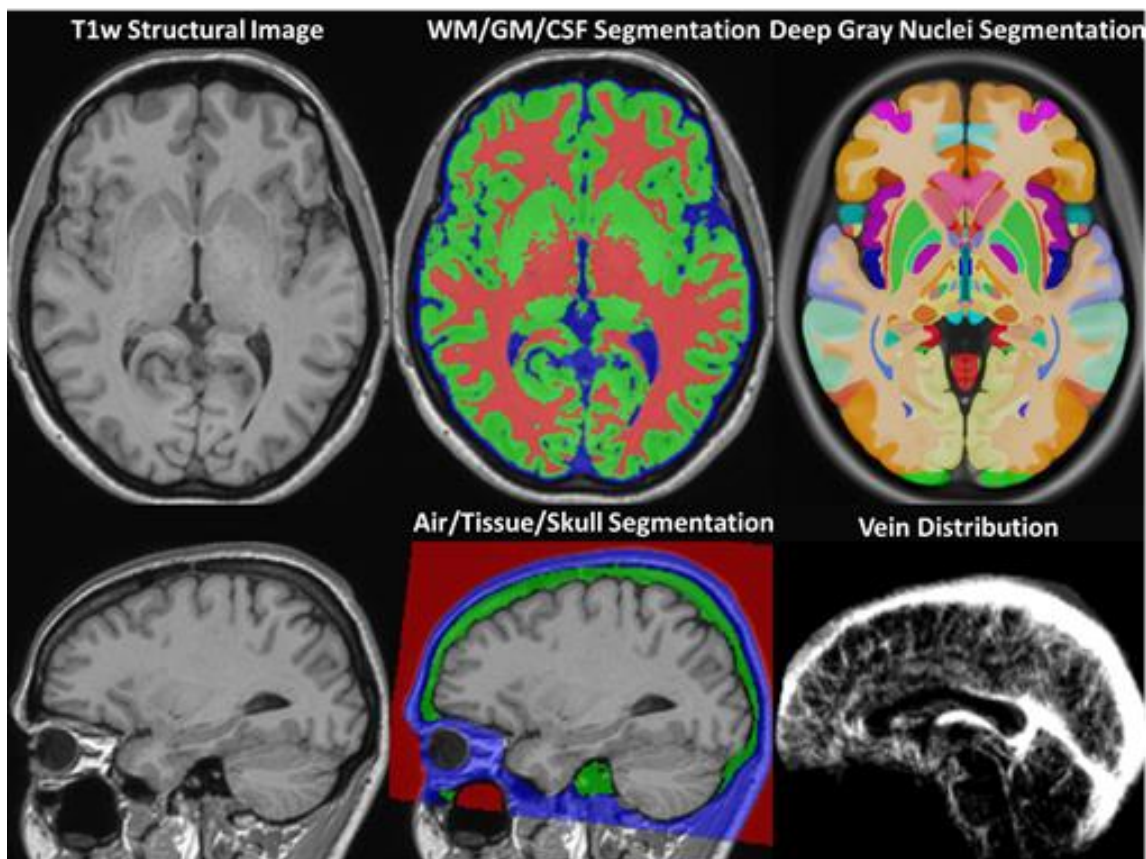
An example of the brain segmentation steps. T1-weighted (T1w) anatomy-defining image and WM/GM/CSF, deep gray nuclei, air/tissue/skull segmentations and the vein partial volume map in the same space obtained through explained steps.
